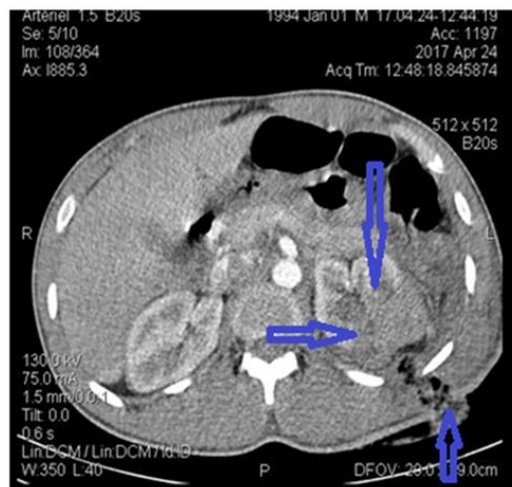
CT urography cross-section showing fracture of the left kidney, medial renal hematoma and path of the bullet with air inlet
